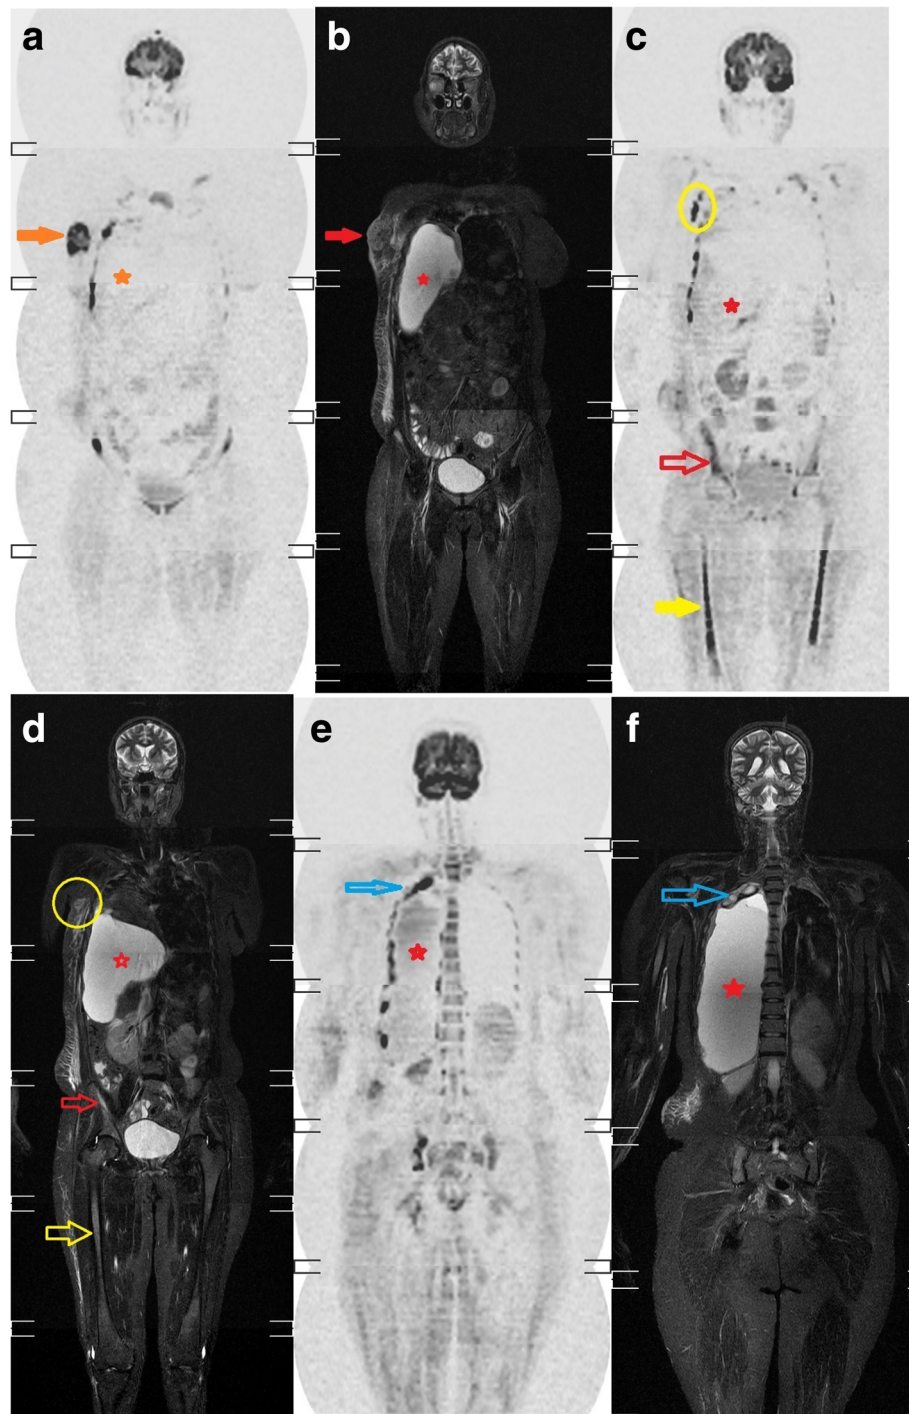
A 54-year-old female patient diagnosed with metastatic breast cancer. a Inverted grey scale coronal WB-DWI and b coronal STIR show the primary right breast cancer (red arrows). c Inverted grey scale coronal WB-DWI and d coronal STIR show metastatic right axillary lymph nodes; the transverse diameter of one of them is 1.3 cm (yellow circle), metastasis of both femurs (yellow arrow) and right iliac bone (red arrow) shown as hyperintensity in STIR and restricted diffusion in DWI. e Inverted grey scale coronal WB-DWI and f coronal STIR show metastatic first right two ribs as well as multiple rib lesions (blue arrows). Marked right pleural effusion is noted in coronal STIR but does not show restricted diffusion in DWI (red stars)
